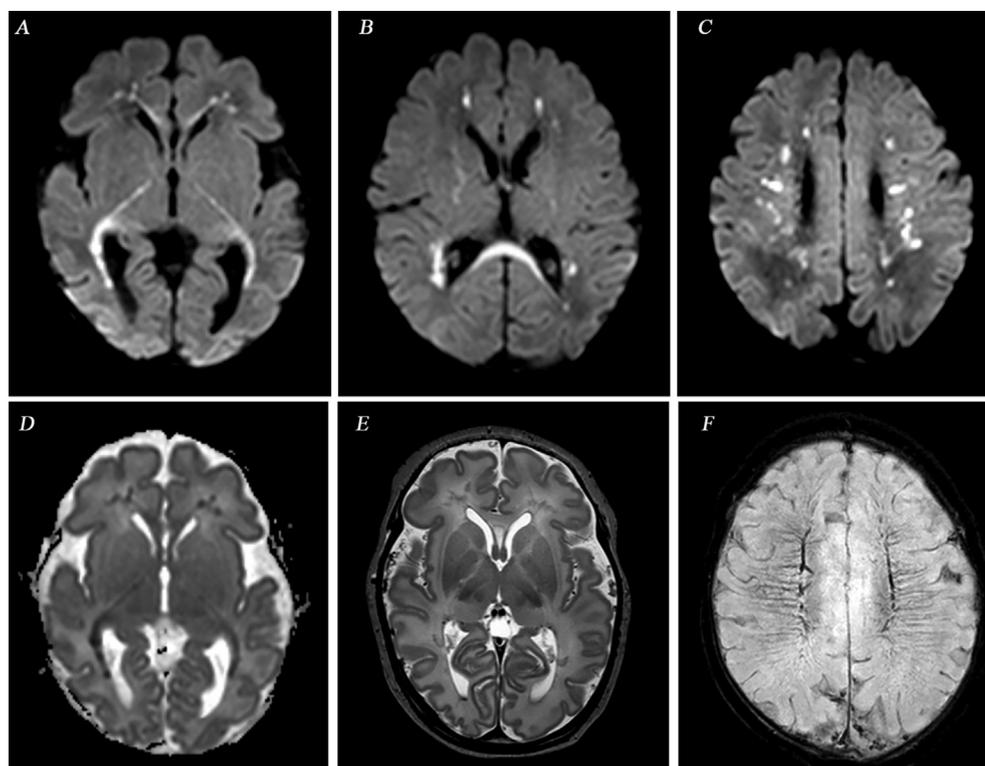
Different patterns of PWMLs shown on an axial MRI performed on day 5, using DWI (A,B and C), ADC map (D), T2 weighted sequence (E) and SWI (F). Areas of increased signal intensity are seen on DWI showing a linear pattern in both frontal lobes (B) and cluster pattern at the midventricular level (C), and involvement of the PLIC and optic radiation (A) and corpus callosum (B) On the ADC map the low signal intensity in the optic radiation and PLIC are less evident than on DWI (D). A small amount of blood is seen in the right occipital horn (E). The SWI supports the ischemic nature of the PWMLs (F). The infant's developmental quotient on the GDMS at 42 months was 103.
